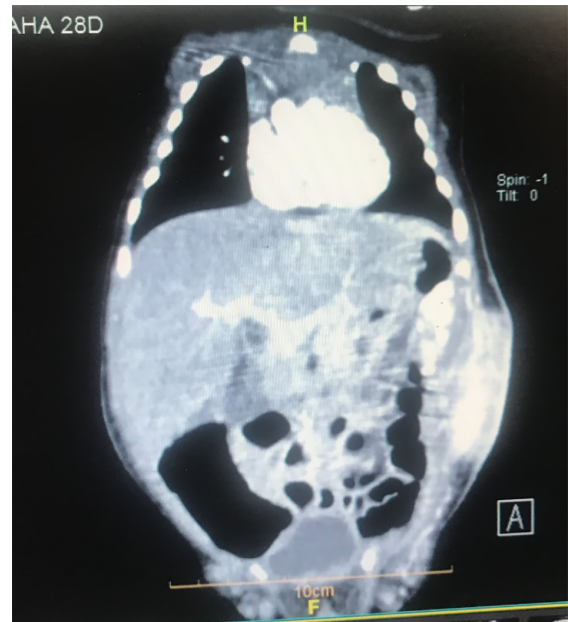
Spiral CT angiography of abdomen showed a large enhancing mass in left side of the abdominal wall involving left oblique and transverse abdominis muscles along with transversalis fascia in medial aspect.
